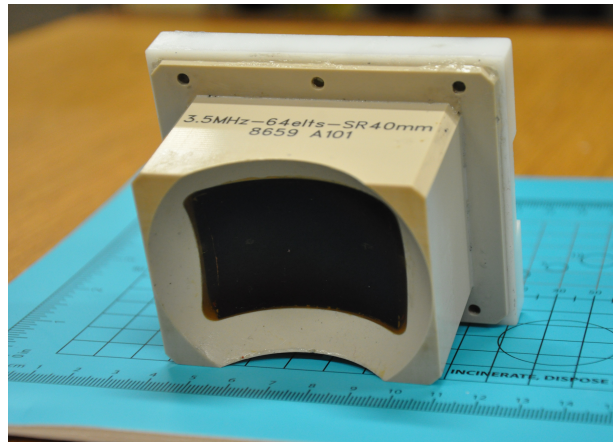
An image of the dual-mode ultrasound array (DMUA).
